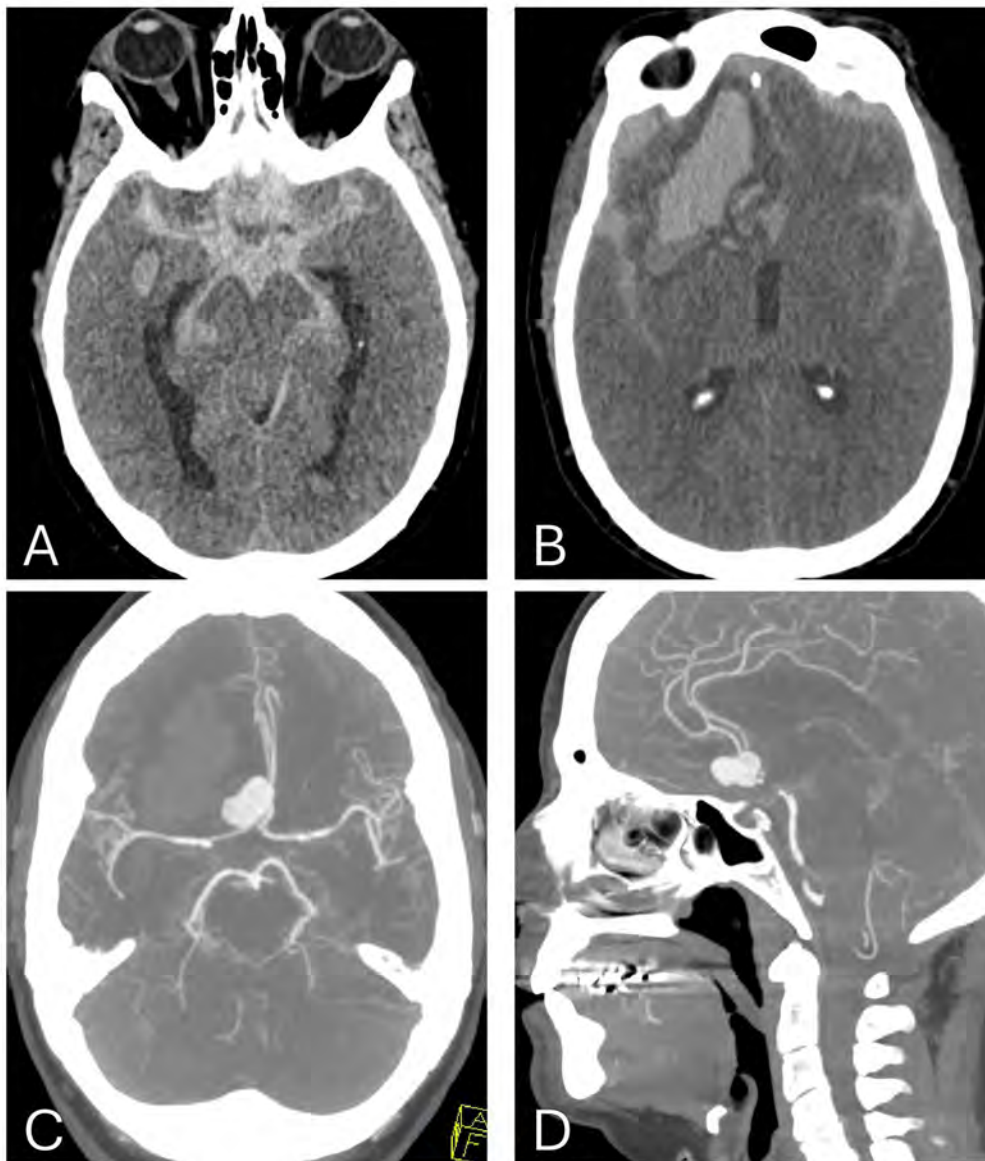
Axial non-contrast head CT (A and B) showing extensive subarachnoid and right frontal parenchymal hemorrhage secondary to ruptured anterior communicating artery aneurysm visualized on axial and sagittal CT angiogram images (C and D).
